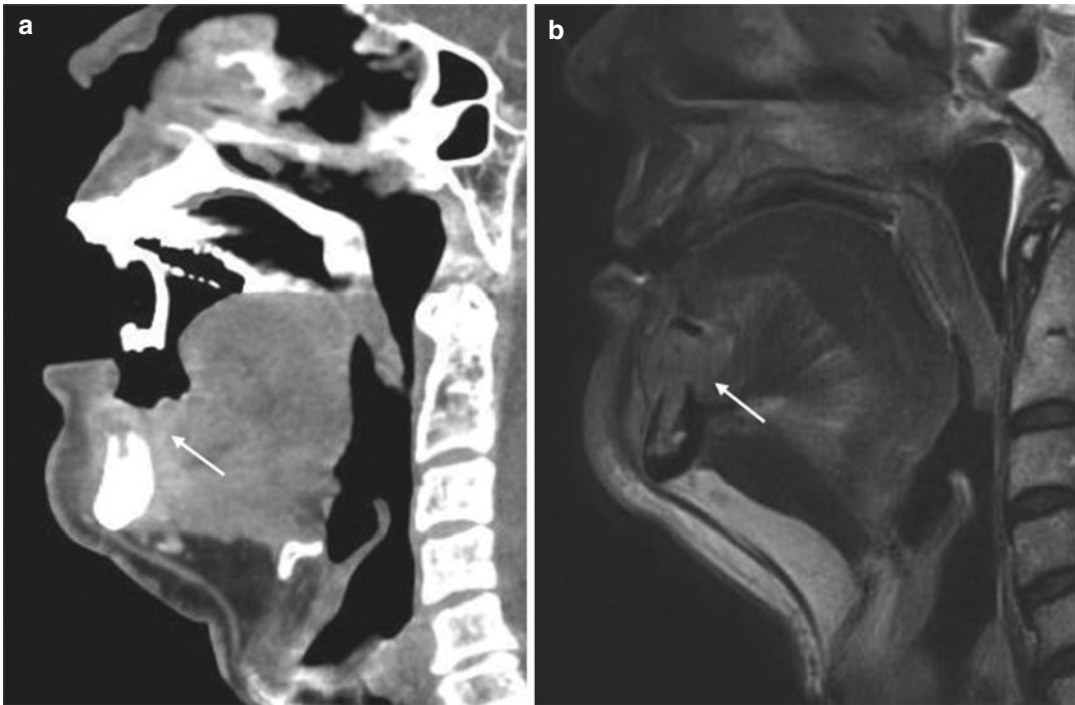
Mandibular bone invasion (white arrow) from squamous cell carcinoma of the head and neck. (a) CT scan. (b) MR T2w image
